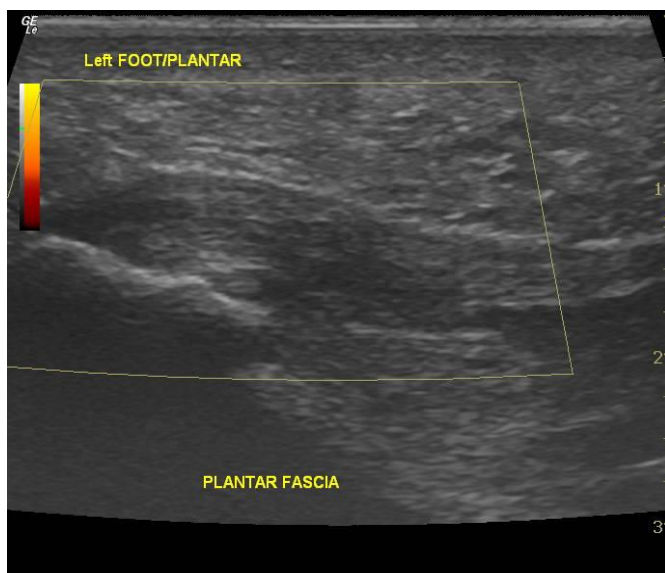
Left plantar fasciitis in a longitudinal view. It is thickened and shows no vascularity on power Doppler study
